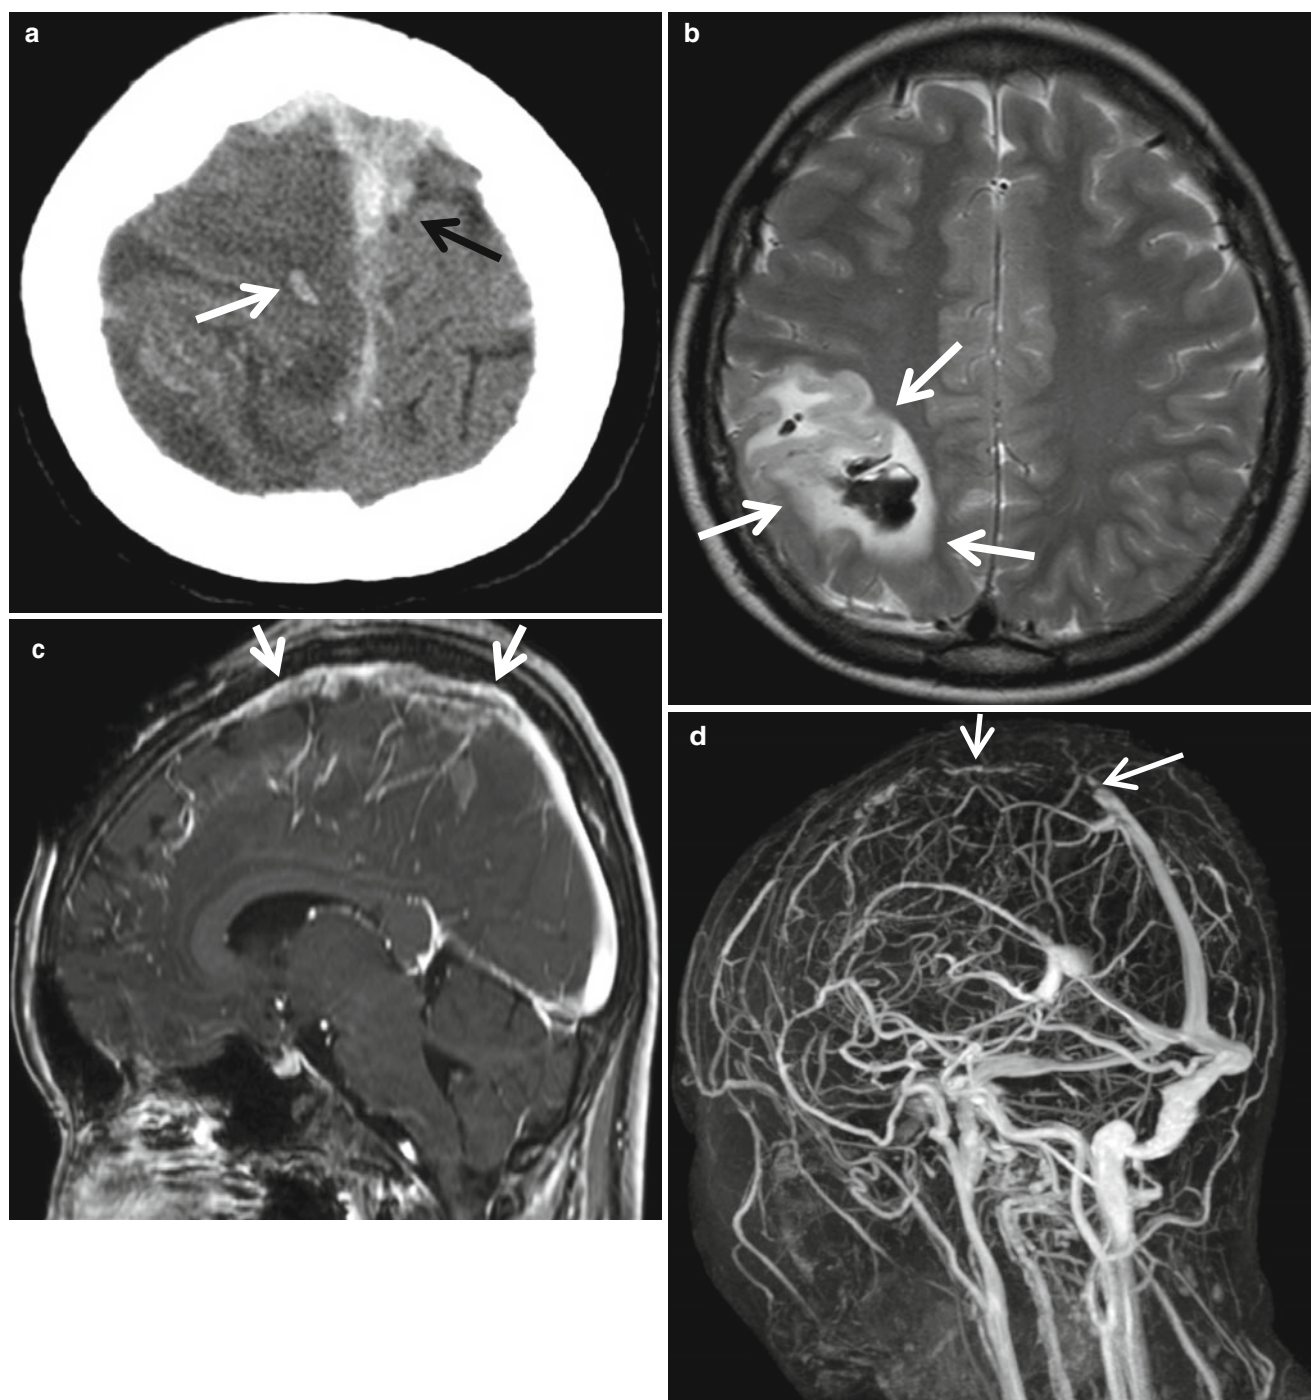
Venous infarct, secondary to the superior sagittal sinus thrombosis. (a) Precontrast CT shows hyperdense superior sagittal sinus (black arrow) and adjacent parenchymal edema with hemorrhage (white arrow). (b) T2-weighted image shows large mass-like lesion containing hemorrhage and edema (arrows). (c) Postcontrast sagittal
